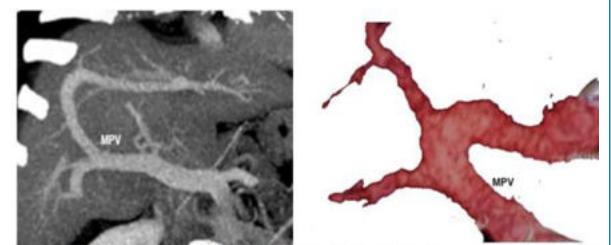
CT axial reformatted MIP and VR image in the portal venous phase showing the absence of bifurcation
